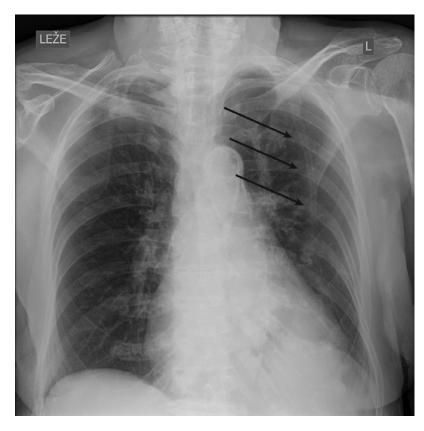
A chest radiography. Anteroposterior view demonstrating vertical bone structure joining the third rib posteriorly on the left side. Progressive reduction of the craniocaudal diameter of the structure is noticed.
